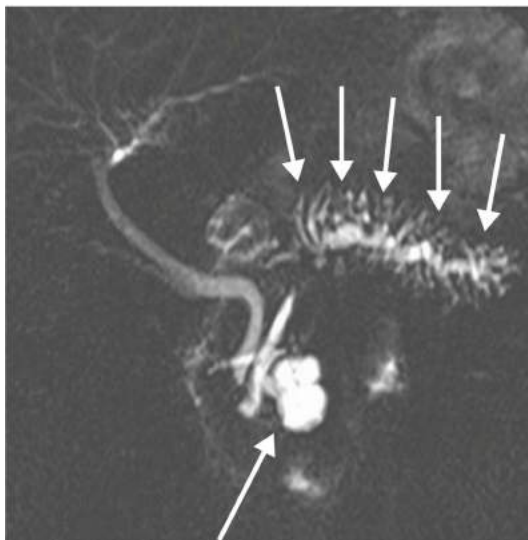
• MRI 2 years after transgastric debridement showing dilated main and side branch pancreatitis ducts (*short arrows*) in the disconnected tail. The etiology of this patient's pancreatitis was the side-branch IPMN (*long arrow*).
